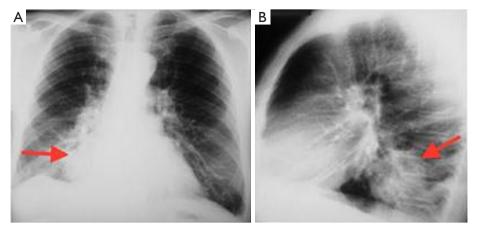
Chest radiography was showing a mass (arrows) over the right lower lung in the topography of the inferior pulmonary vein (A,B).
